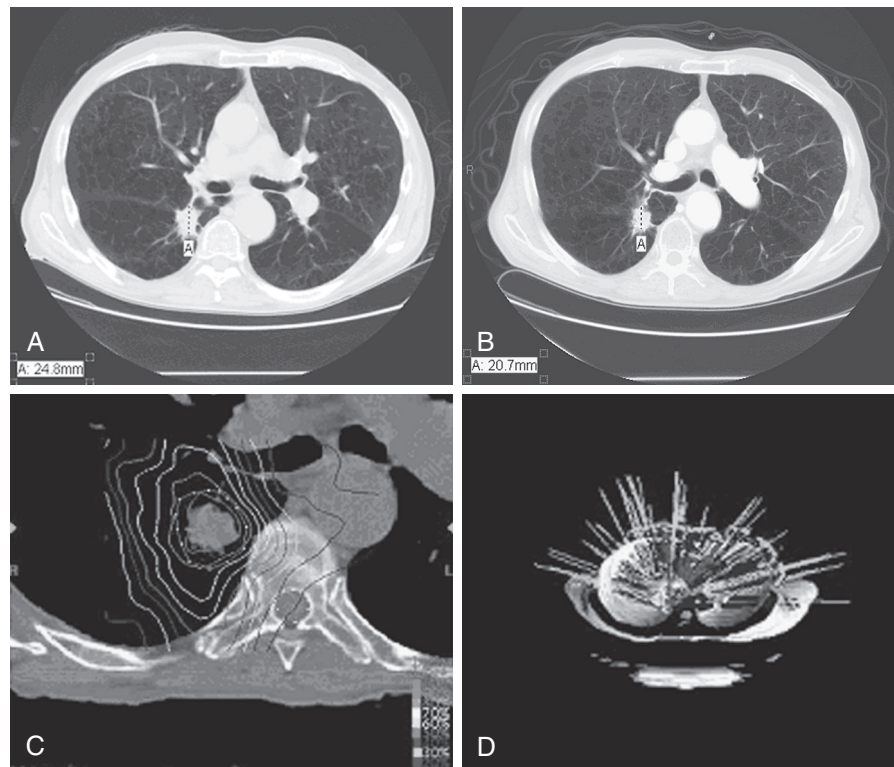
■ Computed tomographic scans of right lung squamous carcinoma treated with CyberKnife stereotactic radiosurgery (SRS). A, Before SRS treatment. B, Three months after treatment. C, Radiation plan with isodose mapping. D, Radiation paths.
